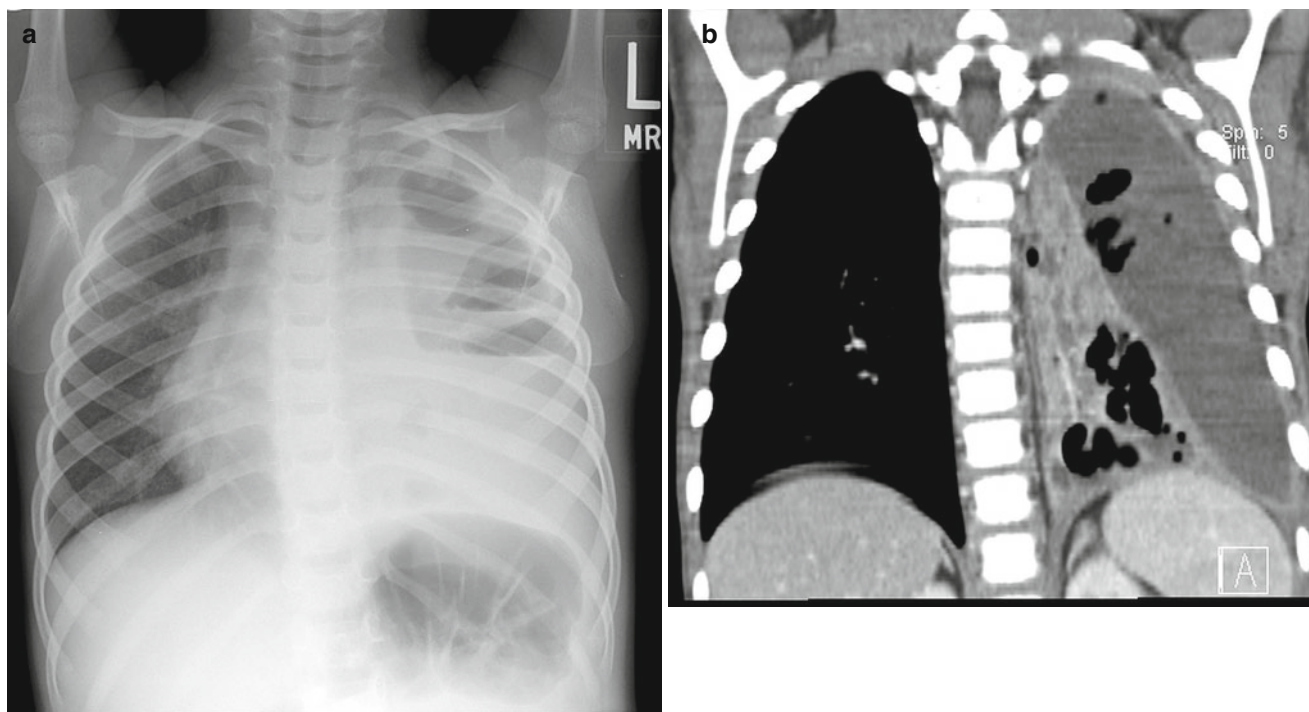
Bronchial pneumonia with abscess. (a) The CXR shows a moderate left-sided effusion with fluid filled cystic spaces concerning for necrotizing pneumonia resulting in the shift of mediastinal structures to the right. (b) The corresponding chest CT shows a large loculated
